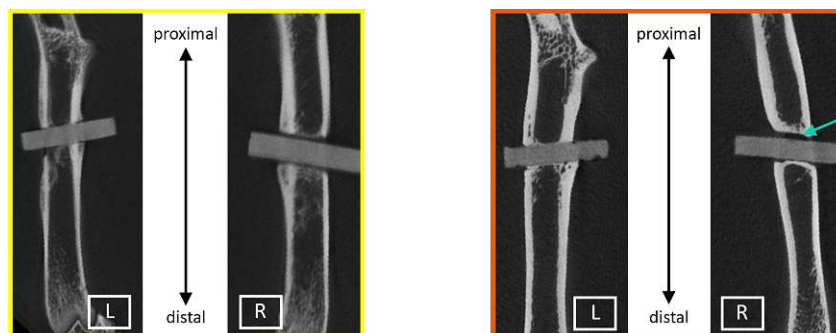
μ CT images of the left and right femur (ID: 2466) depict distinct conditions. Yellow: 2 weeks post-implantation. Orange: 24 weeks post-implantation. The left side shows a tight bone-implant interface without gaps. Conversely, no network between bone and implant was formed on the right side. A gas bubble is noticeable at the proximal side of the implant (turquoise arrow).
